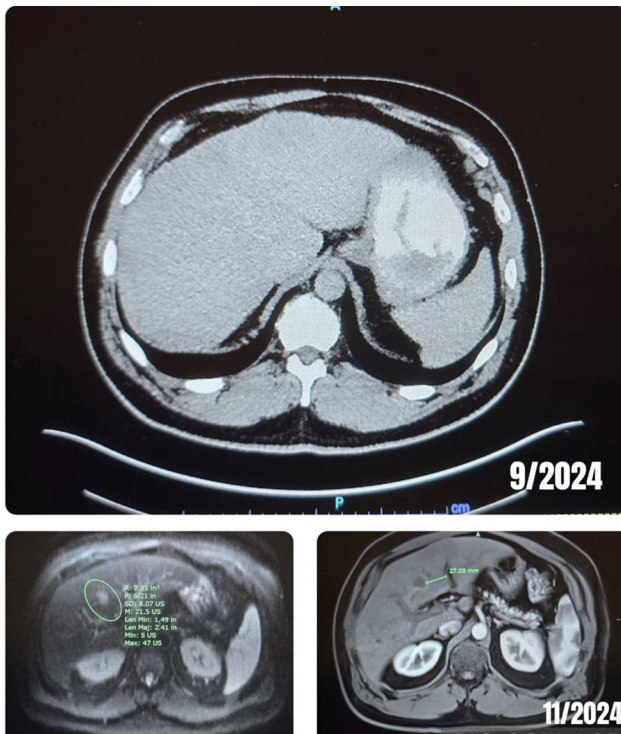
Computed tomography (CT) images of the liver in Case 3. (A) Baseline post-adjuvant surveillance CT shows no evidence of recurrent disease. (B) Subsequent imaging obtained after persistent ctDNA positivity reveals a central hepatic lesion (arrow), later confirmed on MRI and surgically resected.
